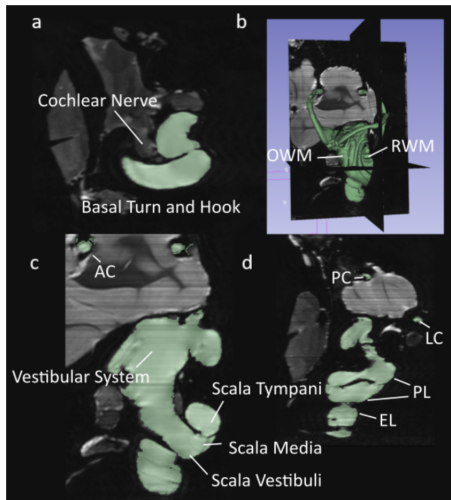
Segmented  $\mu$ MRI scans of the chinchilla subject with key structures labeled. See Table 3 for symbol definitions. The lymphatic fluid of the inner ear is shown in green. (a) Transverse plane (b) 3D view of the entire segmentation (c) Saggital plane (d) Coronal plane
